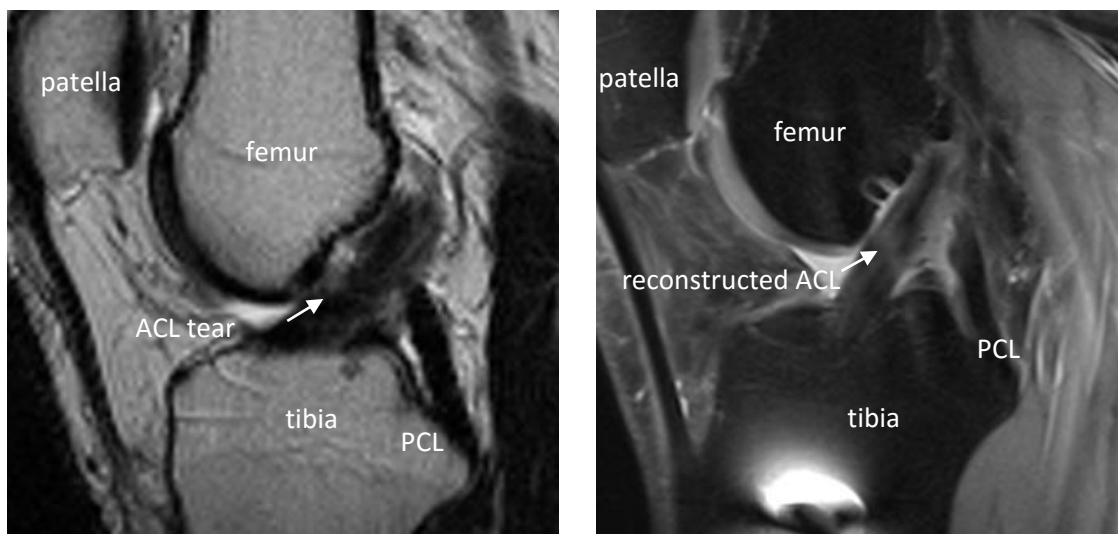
MRI image of anterior cruciate ligament tear and replaced ligament (Source: Pécs Diagnostic Center, Own material).
